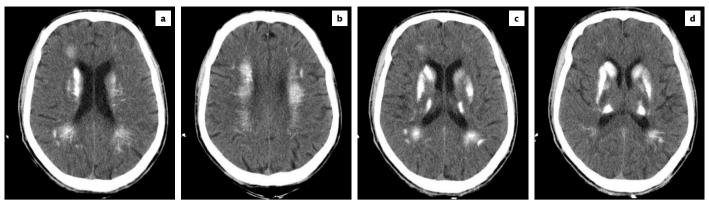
a-d. Computed tomography of the patient. Patient has calcified hyperdense areas in bilateral basal ganglia, thalamus and centrum semiovale.
